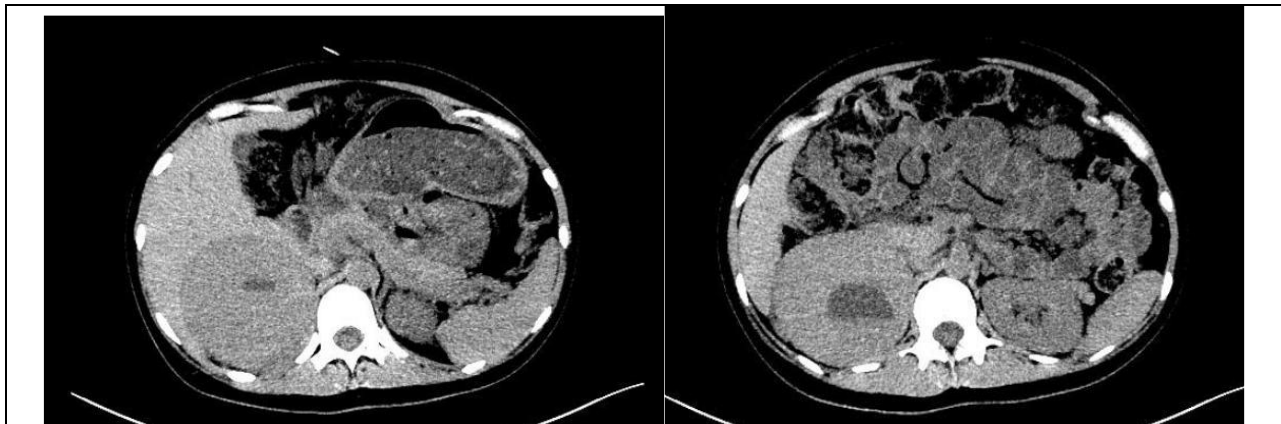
(a) the CT scan of the Pheochromocytoma on February 27, 2024; (b) the CT scan of the Pheochromocytoma on March 21, 2024.
